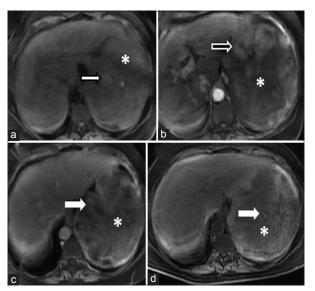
Dynamic contrast-enhanced magnetic resonance imaging (CEMRI) of the liver with hepatocyte specific contrast (Gd-BOPTA) (a) T1-weighted non-enhanced axial sequence of upper abdomen showing hyper intense area (bold white arrow with black outline) within the mass lesion (*) suggestive of hemorrhage (b) T1-weighted CEMRI axial sequence in arterial phase of the upper abdomen demonstrating areas of hyper vascularity (white arrow) in the peripheral portion of the left subdiaphragmatic mass lesion (*) (c) T1-weighted CEMRI axial sequence in equilibrium phase showing heterogeneous spoke wheel pattern like enhancement (bold white arrow) of the mass lesion (*) (d) T1-weighted CEMRI axial sequence in hepatobiliary phase showing diffuse hypointense signal of the mass (*) with heterogeneous spoke wheel pattern and partly enhancing central scar (bold white arrow)
